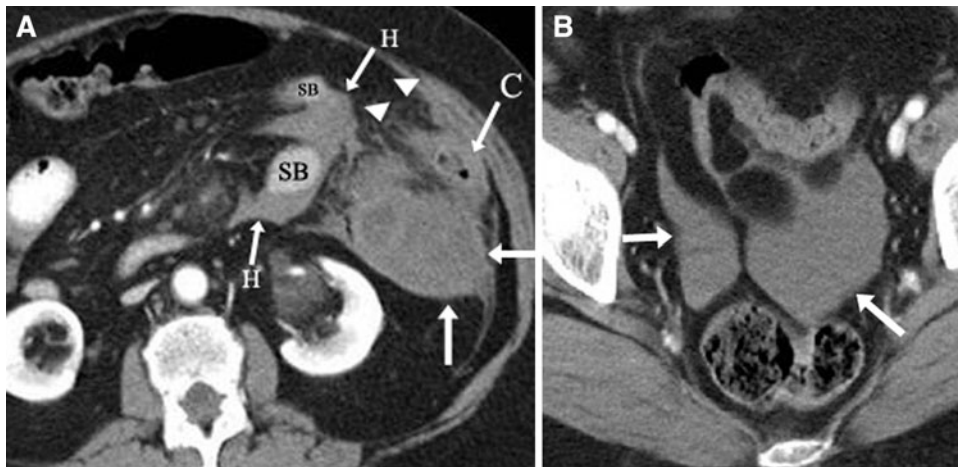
A 64-year-old female status post-blunt abdominal trauma. A Axial contrast-enhanced CT of abdomen demonstrated thickened descending colonic wall (*C*) with pericolic fat stranding (*arrowheads*) and with an adjacent large fluid collection (*arrows*) in the left anterior pararenal space.
